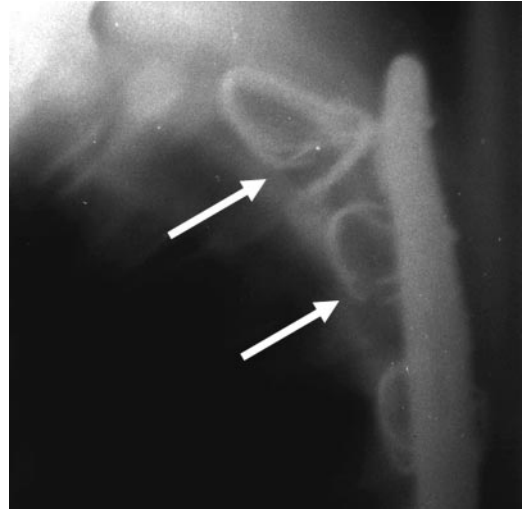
Fracture of sublaminar wires used in corrective surgery for scoliosis. Routine surveillance radiograph demonstrates the fracture of multiple wires (arrows) and recurrent kyphosis of the thoracic spine anterior to the instrumentation.
